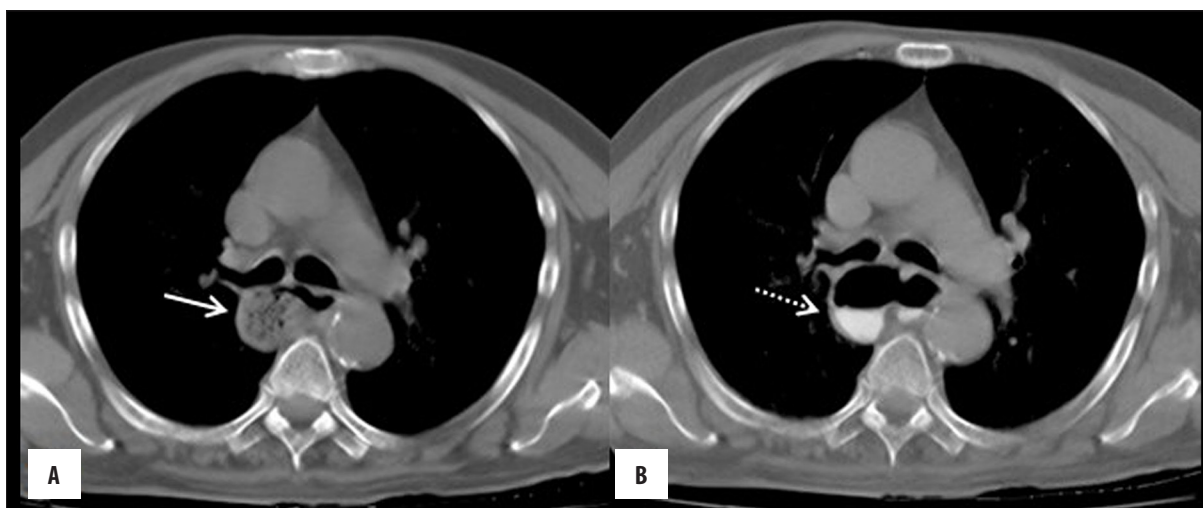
(A, B) Axial CT chest in mediastinal window showed retained food particles in the diverticulum (solid arrow) and retained oral contrast in the dependent location (dotted arrow).
